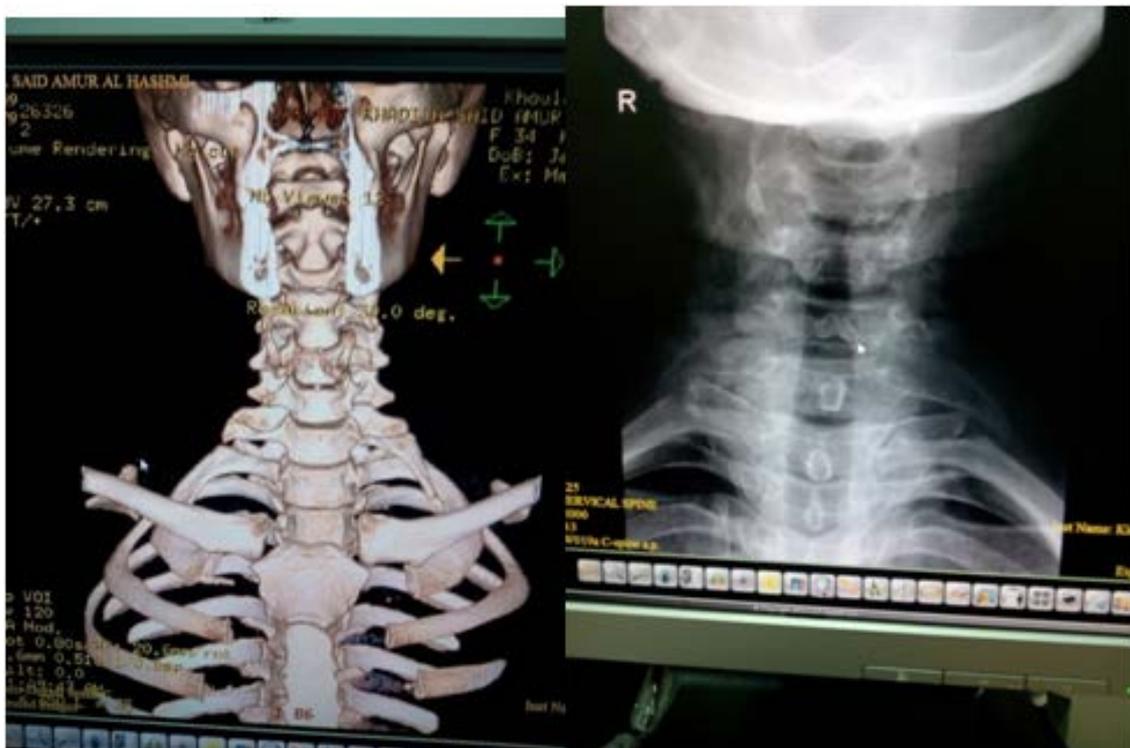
CT and X ray of patient no 4 showing left sided cervical ribs
